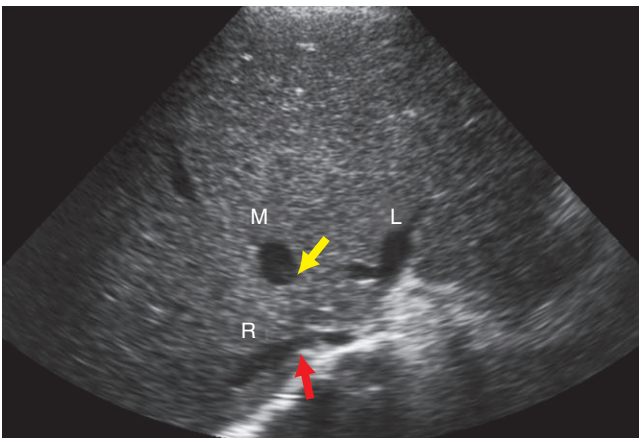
The transverse sonographic image of the liver shows a very narrowed right hepatic vein (R, red arrow) and distal thrombosis/occlusion of the middle (M, yellow arrow) and left (L) hepatic veins near where they normally communicate with the IVC.
